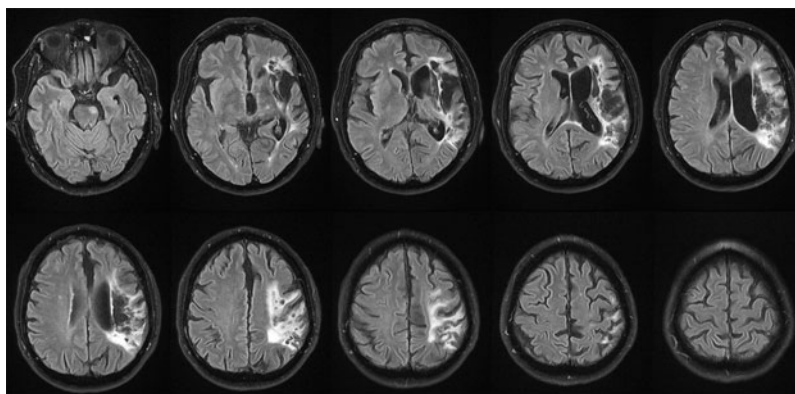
MRI images from a T2-weighted fluid attenuation inversion recovery sequence showing the sequels of the right ischemic stroke of patient #2 39 months after the lesion, suggesting cerebral atrophy, encephalomalacia in the frontal, parietal, and insular cortex of the right hemisphere, and discrete ventricular asymmetry; and Wallerian degeneration in the descending right white matter tract. There was no trace of acute ischemic lesion.
